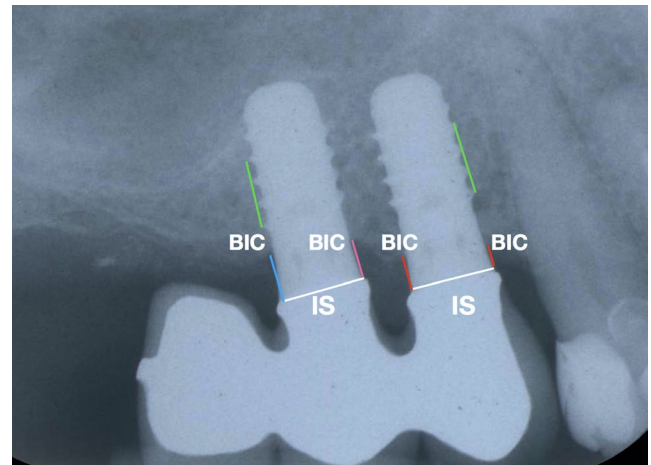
Radiographic reference points and lines used to measure linear peri-implant marginal bone levels of the fixed dental prosthesis (FDP) with cantilever extension. IS: Implant Shoulder BIC: radiographic Bone-to-Implant Contact Linear distance between implant threads ($3 \times 1.25 \text{ mm} = 3.75 \text{ mm}$) (green) Implant without cantilever extension: Mesial and distal linear distances IS-BIC (red) Implant with cantilever extension: Linear distance IS-BIC distant from cantilever extension (pink) Implant with cantilever extension: Linear distance IS-BIC adjacent to cantilever extension (blue)
